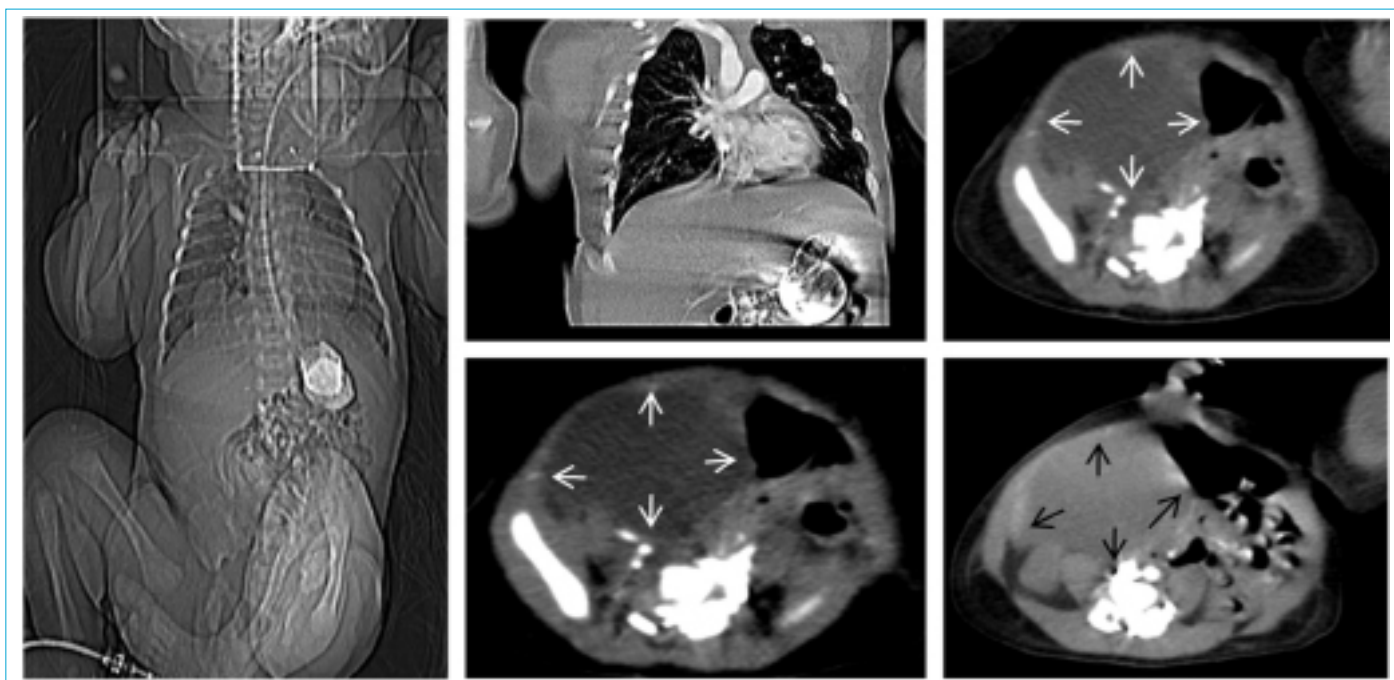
Contrast enhanced abdominal CT scans of the patient.
